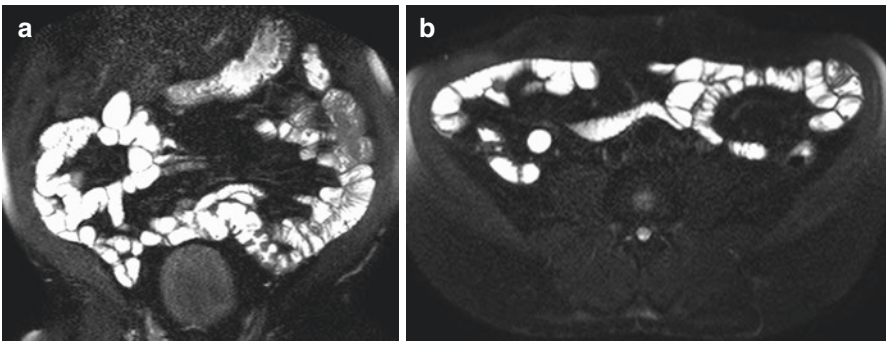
Coronal (a) and axial (b) fat-suppressed moderately T2-weighted images obtained with an effective echo time of 80 ms. This series is ideally performed after gadolinium administration
